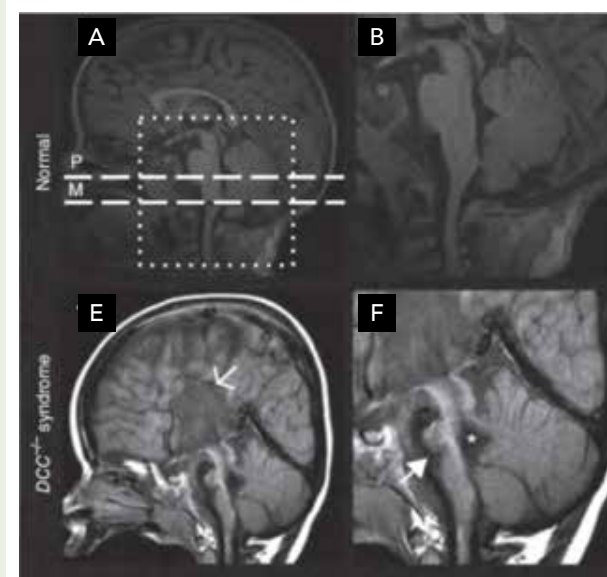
MRI scans of a child without developmental split-brain syndrome (images A, B, C and D), in comparison to a child with the syndrome (images E, F, G and H).
